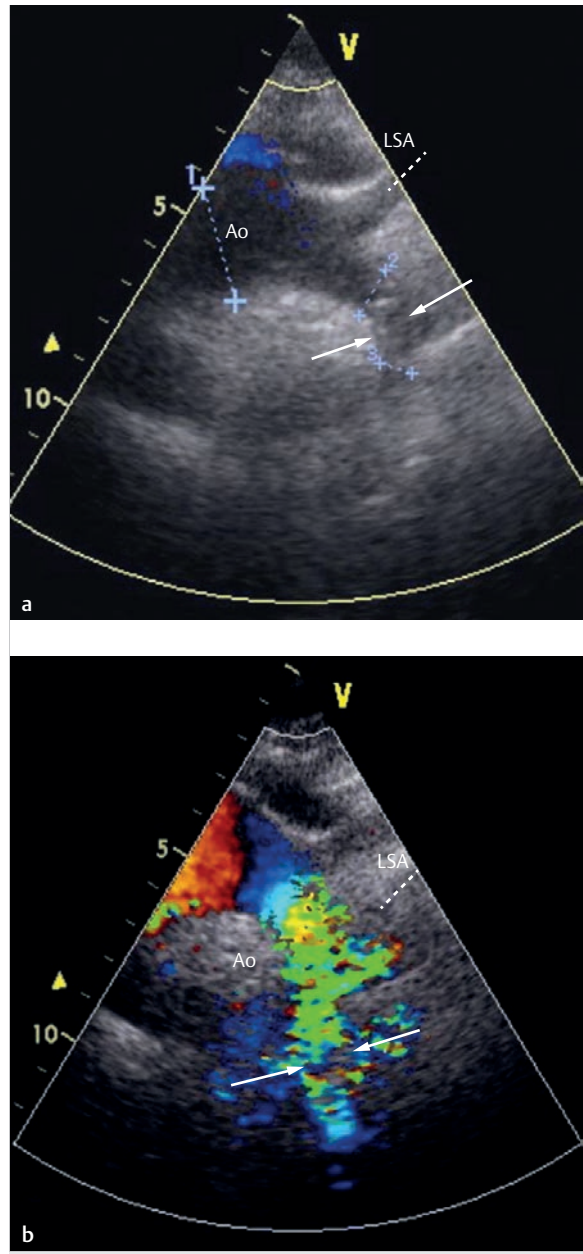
Combination of ultrasound, X-ray, and angiography. Diagnosing and treating recoarctation via stent implant.
